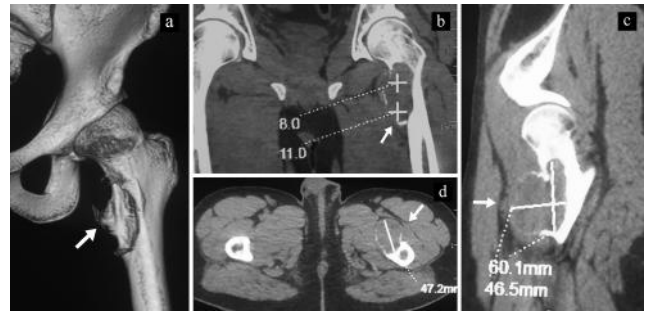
CT reconstruction hip delineates expansile lytic bone cyst, white arrow showing thinned cortex in 2a, medial femoral orientation of cyst on sagittal view in 2b, ballooning of cortex in 2c and 2d
